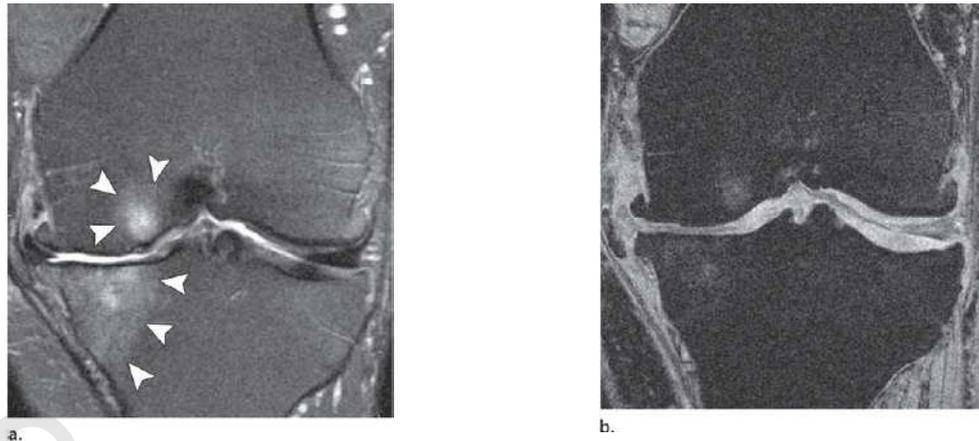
(a) Coronal T2-weighted fat-suppressed image shows large areas of complete loss of cartilage in the medial tibiofemoral compartment with associated edematous degenerative lesions in subchondral bone marrow (arrowheads). Large osteophytes and medial meniscal extrusion also are seen. (b) Coronal 3D FLASH image accurately depicts the areas of complete loss of cartilage in the medial compartment as seen in a, but the associated bone marrow lesions are barely visible.⁽⁵²⁾
